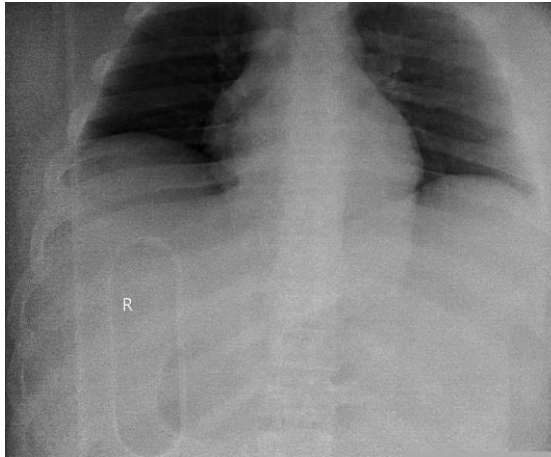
Preoperative portable anteroposterior chest X-ray
